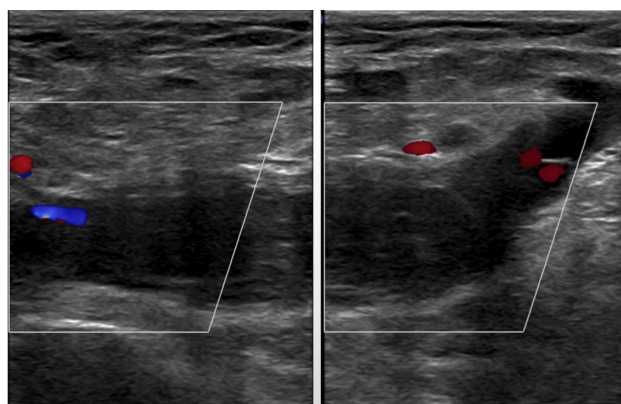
Lower limb vascular Doppler ultrasound: The blood flow in the right lower limb shows a thin line, intermittent short rod shaped blood flow signal, and no obvious blood flow signal is observed in some lumens.
